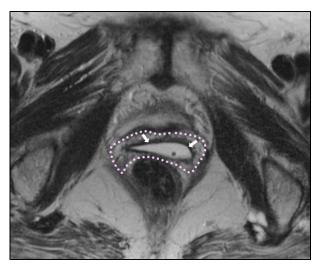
Vaginal anatomy on axial T2 FSE MRI. Gel (bright signal) was injected into the vagina to improve depiction of low-signal intensity vaginal wall (white arrows). Vagina and paravaginal tissue is contoured with dotted pink contour. Anteriorly, this region borders to bladder/urethra, posteriorly to mesorectal fascia and lateraly to the pelvic floor muscles/ischiorectal fossa.
